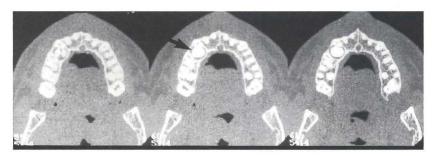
Axial CT scans show that the crown of the mesial tooth is between the buccal and palatal bone plates (arrow).
